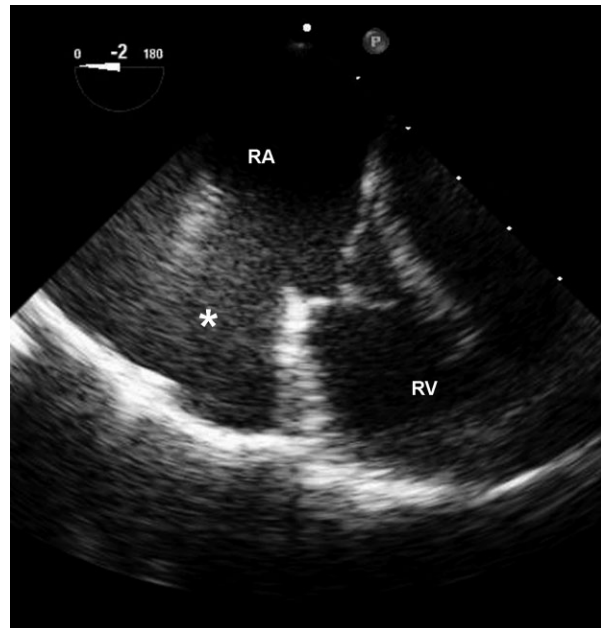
Case 3. Preoperative transesophageal echocardiogram. RA, right atrium; RV, right ventricle. *Giant right atrial aneurysm.
